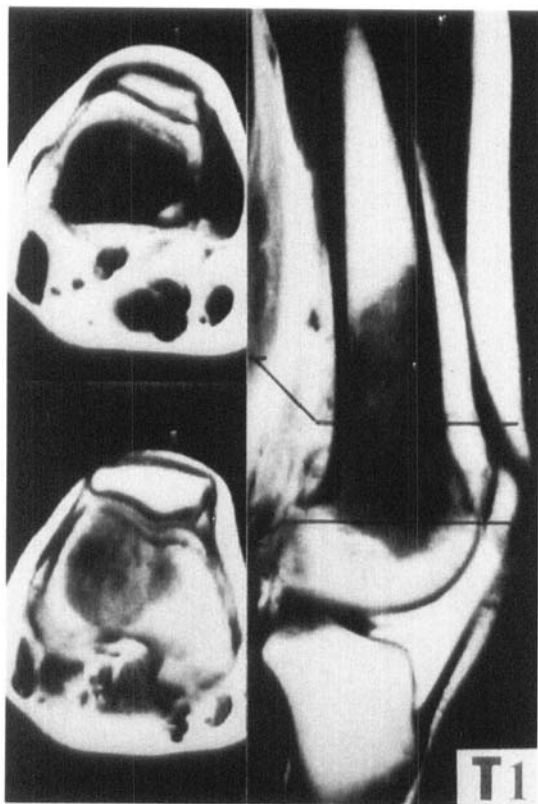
T1-weighted MR image of a knee joint clearly showing fatty, connective tissue and superficial synovium with high signal intensity and transitional area between the articular cartilage and periosteum with low signal intensity.
